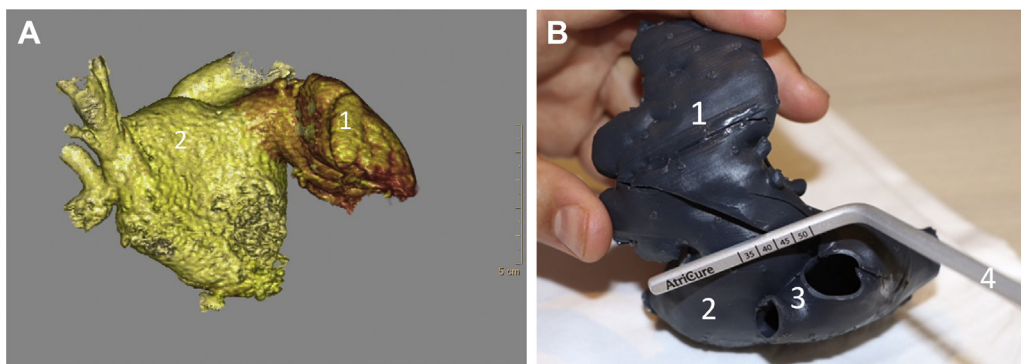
A: Front view of a computed tomography scan reconstruction centered on the left atrial appendage (1), which had a volume comparable to that of the left atrium in this patient (2). B: Modeling of the giant left atrial appendage by the 3-dimensional printer. Measurement of the base of the left atrial appendage is done in order to choose the proper size of the AtriClip device. 1 = Left atrial appendage; 2 = left atrium; 3 = left pulmonary veins; and 4 = calibration clamp (AtriCure, Inc).
